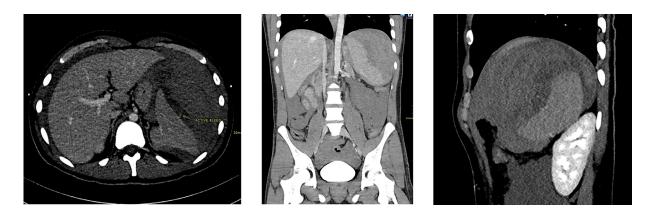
Axial, coronal, and sagittal CT imaging showing an AAST grade IV splenic injury with a potential area of contrast extravasation just lateral to the splenic midpole.
